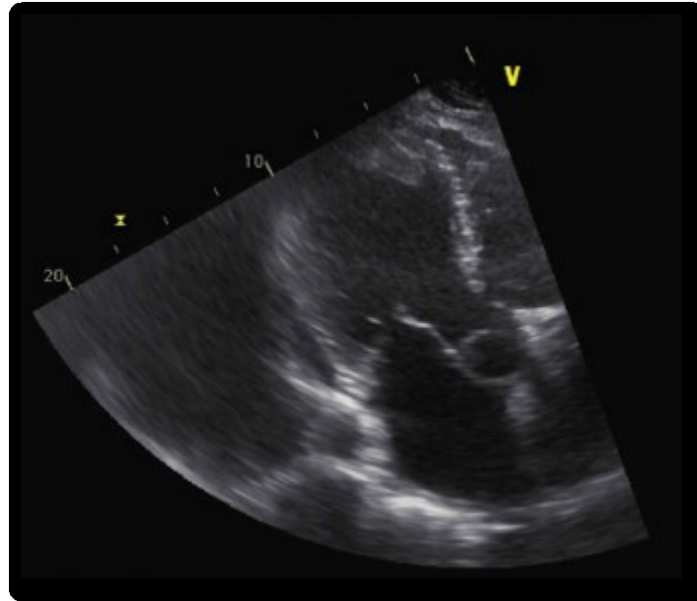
Dilated cardiomyopathy - Four chamber echocardiogram showing left ventricular dilatation
